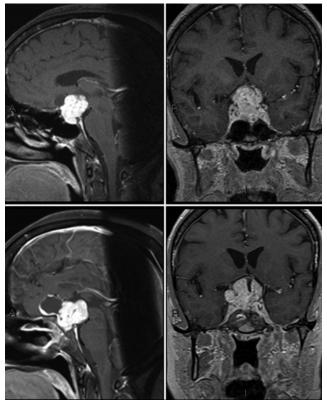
Sagittal and coronal Gd-enhanced T1-weighted MR images obtained in a patient who presented with a large cystic and solid tumor (upper) and experienced progressive growth (lower) for which she declined further treatment.
